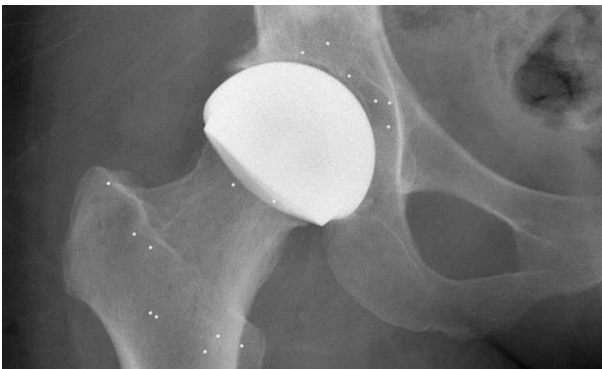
Post Op X-Ray of H1 resurfacing system (Courtesy Embod Orthopaedics Ltd.).
